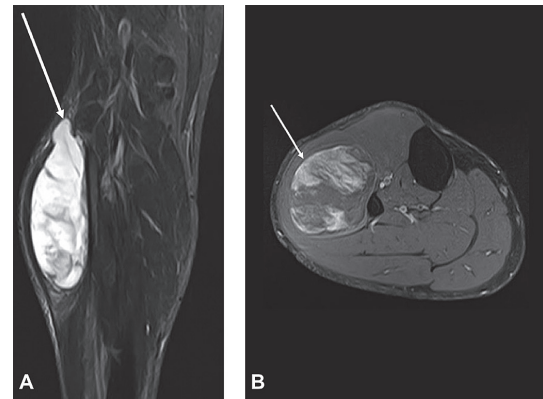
A) MRI in T2 STIR weighted image without contrast in the coronal section revealing a high signal tumor, well-delimited, with septations (white arrow); B) MRI in T1 EAT SAT weighted image with contrast in the axial section demonstrating heterogeneous enhancement of the lesion (white arrow)
